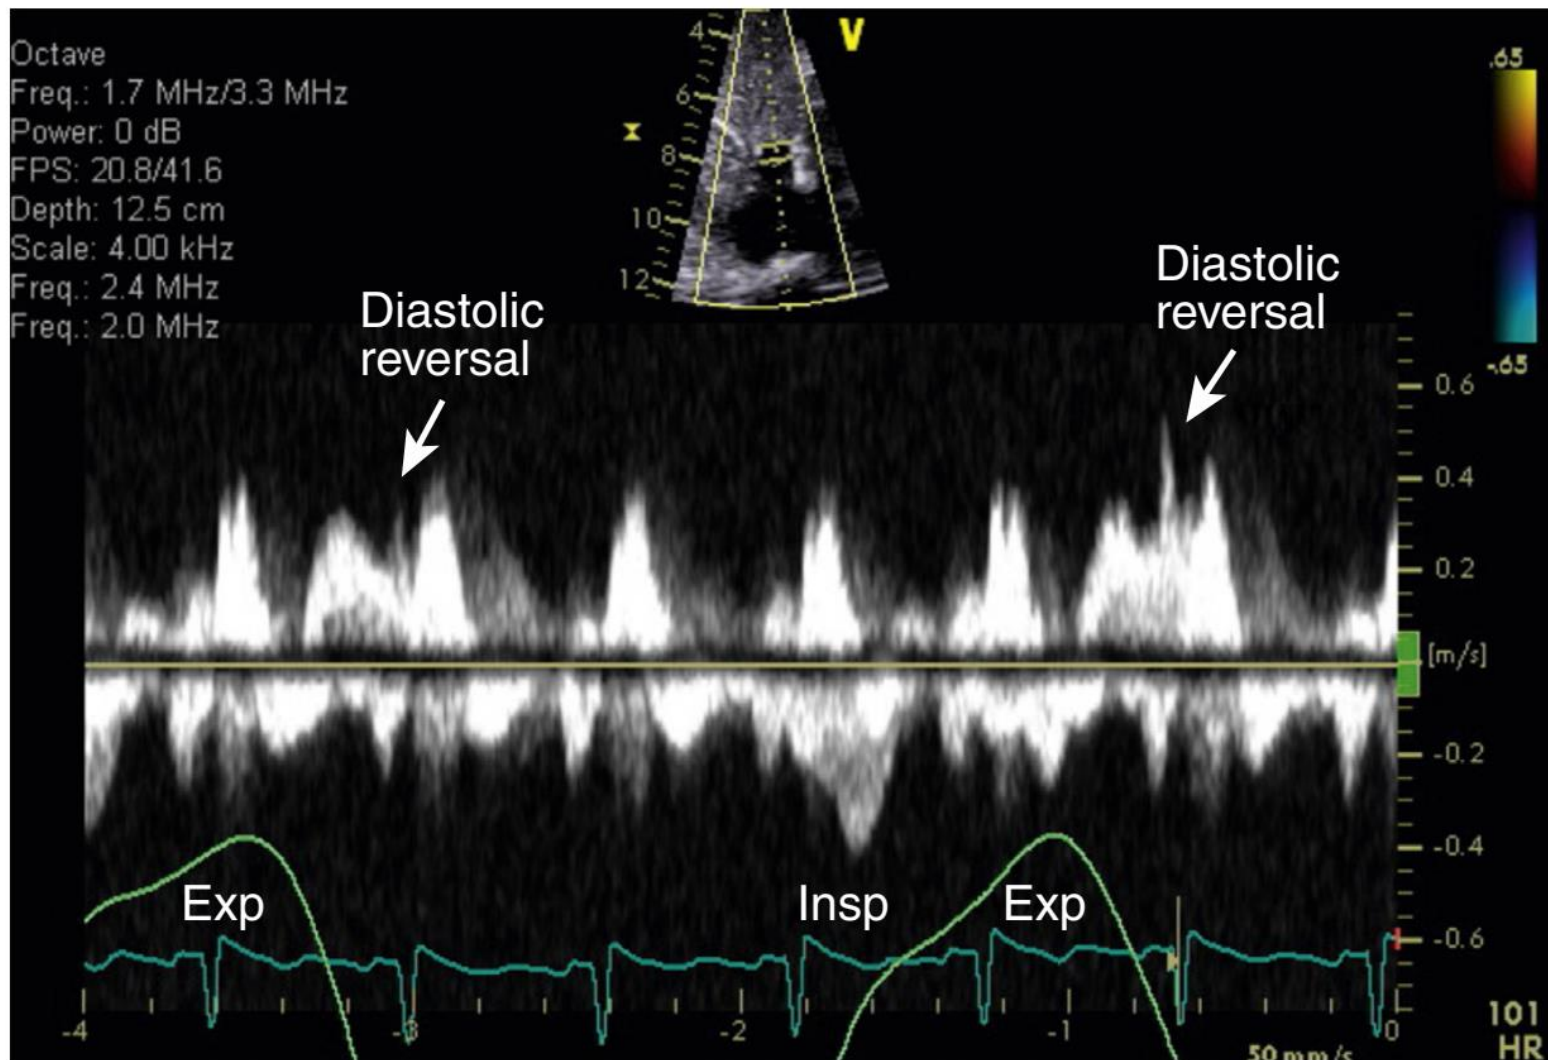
Hepatic venous Doppler profile in tamponade. Inspiration (*Insp*) leads to augmentation of hepatic vein forward velocity. With the onset of expiration (*Exp*), when left heart filling is favored at the expense of the right, hepatic vein diastolic forward flow reverses as indicated.
